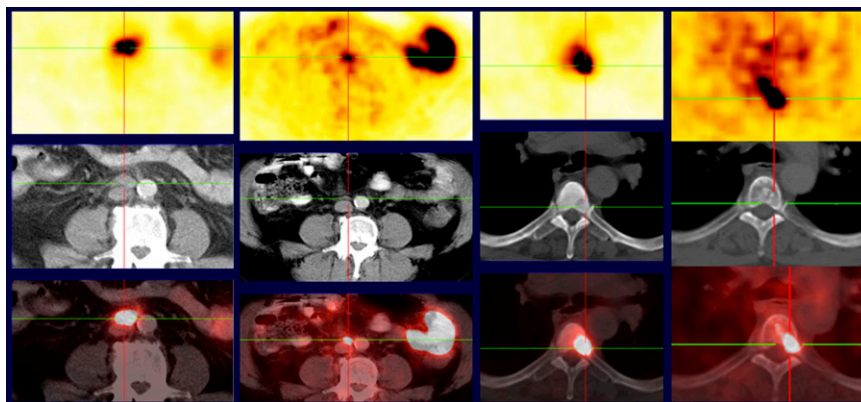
Examples of ^{68}Ga -PSMA-HBED-CC imaging in ^{177}Lu -PSMA-TUM1 therapy for prostate cancer. Left block of images acquired before (left column) and after (right column) therapy shows a significant decrease (89%) in SUV_{max} in the target lesion (paraaortic lymph node metastasis). Right block of images acquired before (left column) and after (right column) therapy shows a significant decrease (78%) in SUV_{max} in the target lesion (T5 vertebra).
